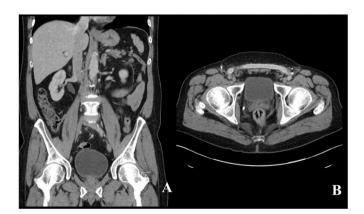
Contrast enhanced CT abdomen and pelvis demonstrating excellent treatment response post chemotherapy, B: Reconstructed vascular graft anatomy.
